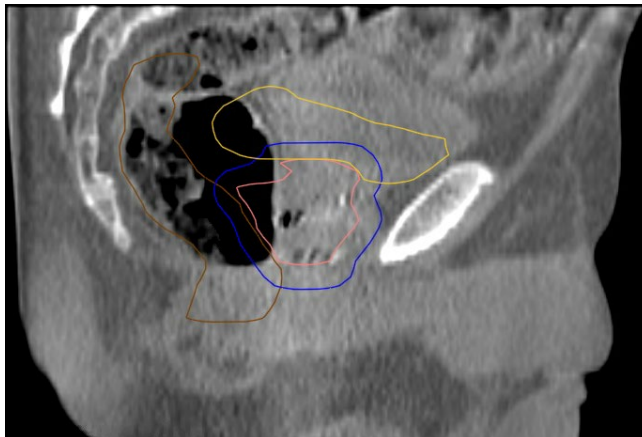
CBCT sagittal view of a prostate cancer patient. The pink, blue, yellow and brown delineations represent the CTV, PTV, bladder and rectum, respectively, and are based on the anatomy of the planning CT. A large gas bubble not present during the planning CT is visible in the CBCT. A small difference in the bladder filling can be seen as well.
